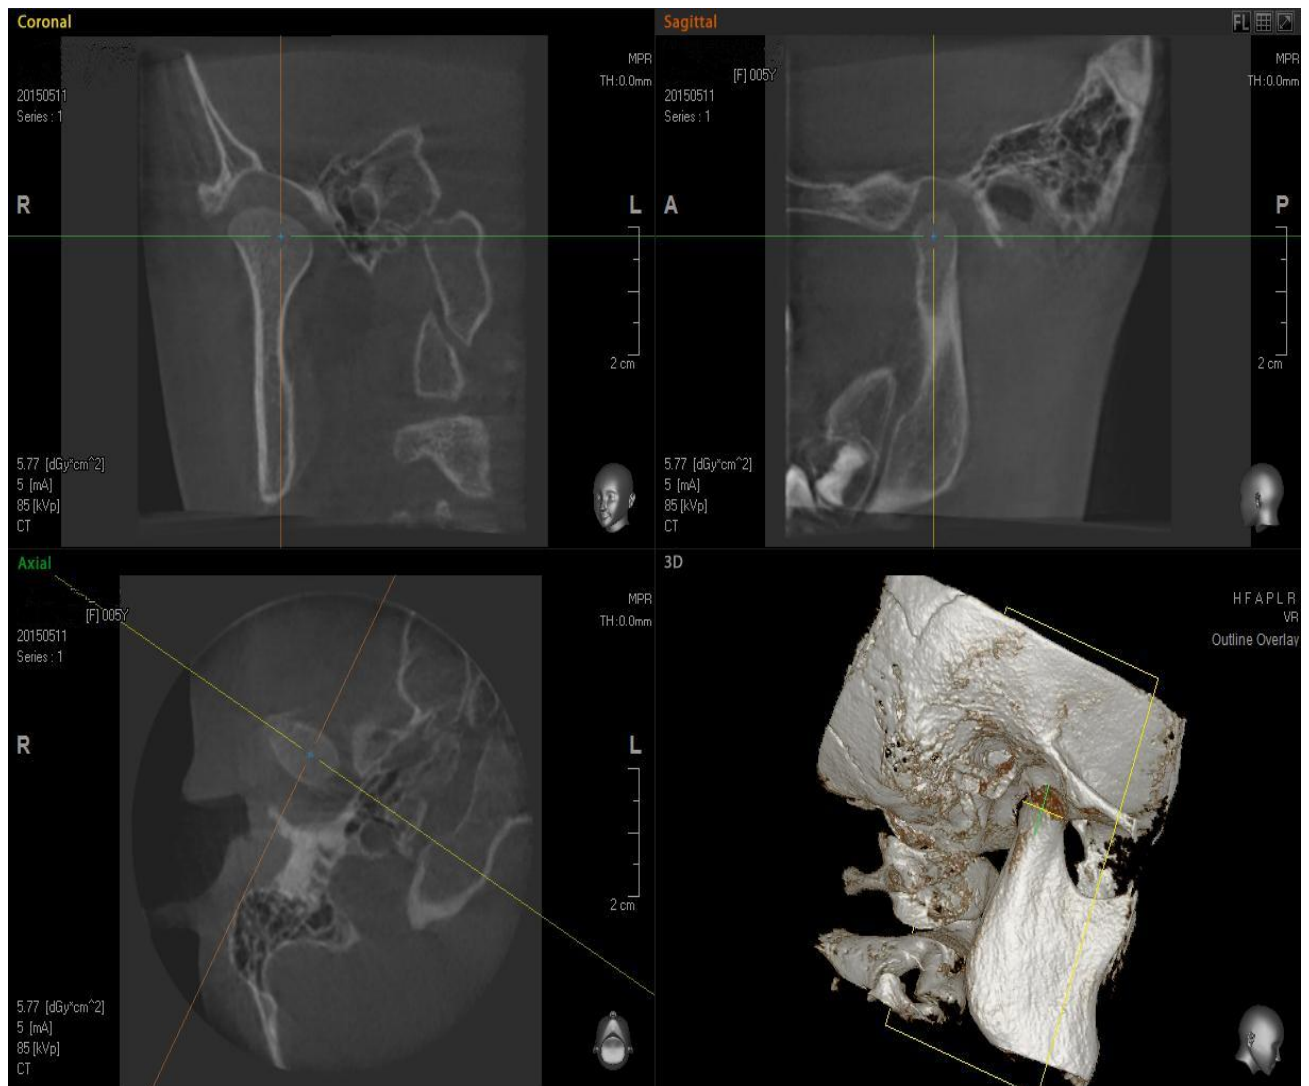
2.5B. The radiographic images of the eight year old patient with explicit joint sounds.
